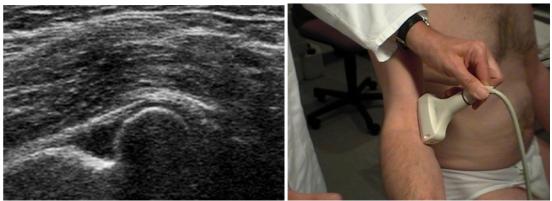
a-c Unusual transducer positions: perineal and arthrosonography (b, c)
